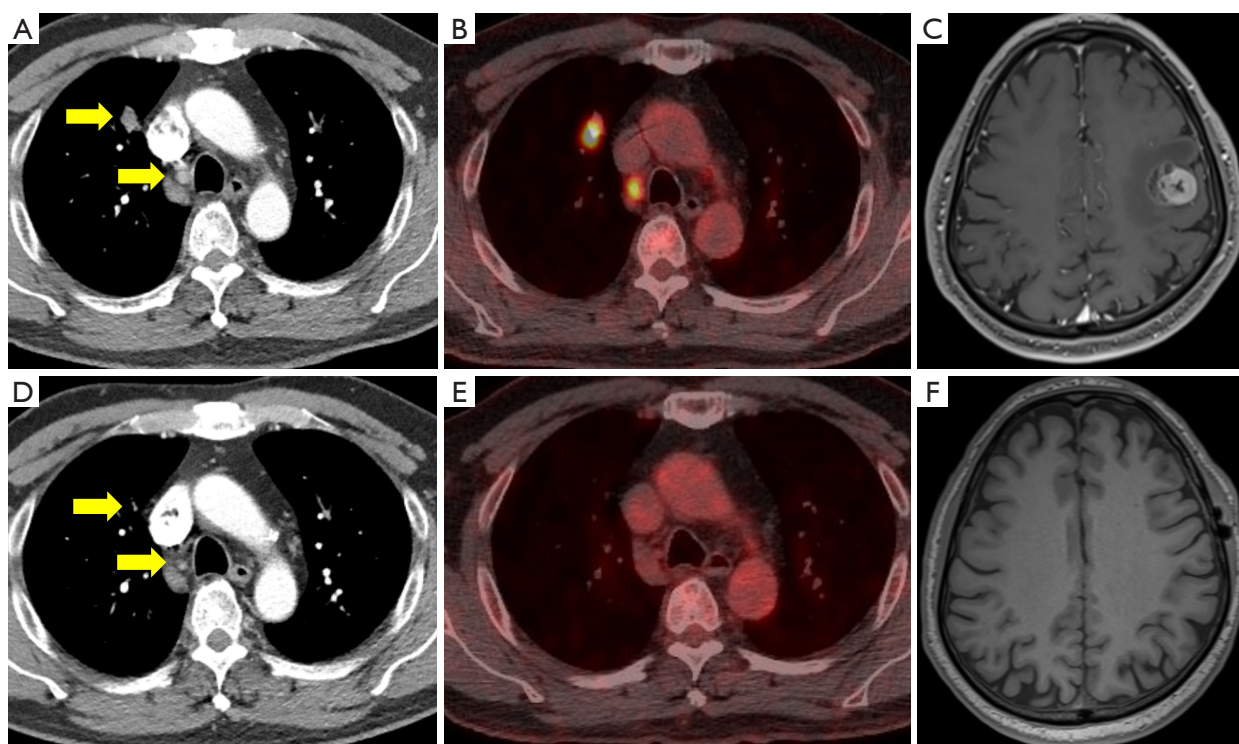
Computed tomography of the chest, positron emission tomography–computed tomography, and magnetic resonance imaging of the brain before and after treatment with lazertinib. (A–C) Before treatment, a 2.1 cm fluorodeoxyglucose-avid nodule in the right upper lobe and right lower paratracheal lymph node enlargement were observed (yellow arrows in the A and D), along with a 2 cm solid mass with hemorrhagic changes and peritumoral edema in the left frontal lobe. (D–F) After 6 months of treatment with lazertinib, a radiologic complete response was observed on follow-up imaging.
